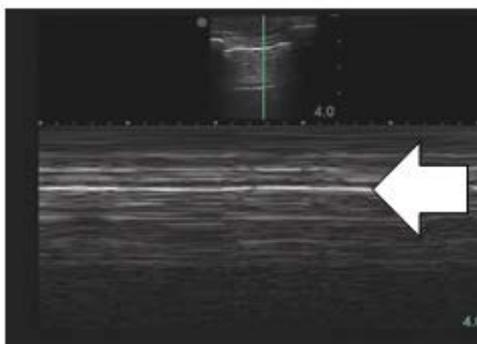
Chest ultrasound for pneumothorax patient showing barcode or stratosphere sign in M mode.
